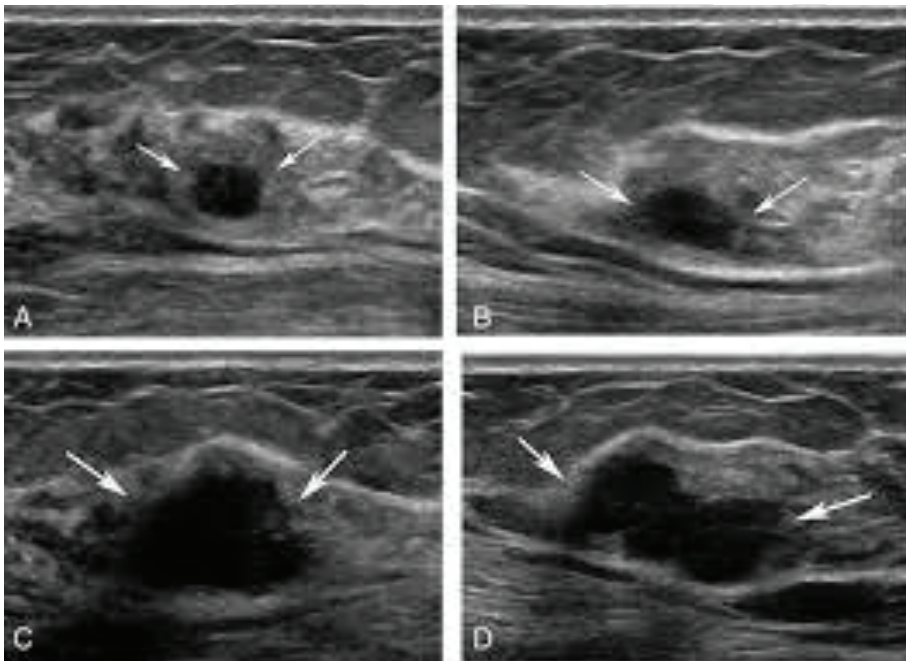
ultrasonography images of a 46-year-old woman diagnosed with left breast invasive cancer.
